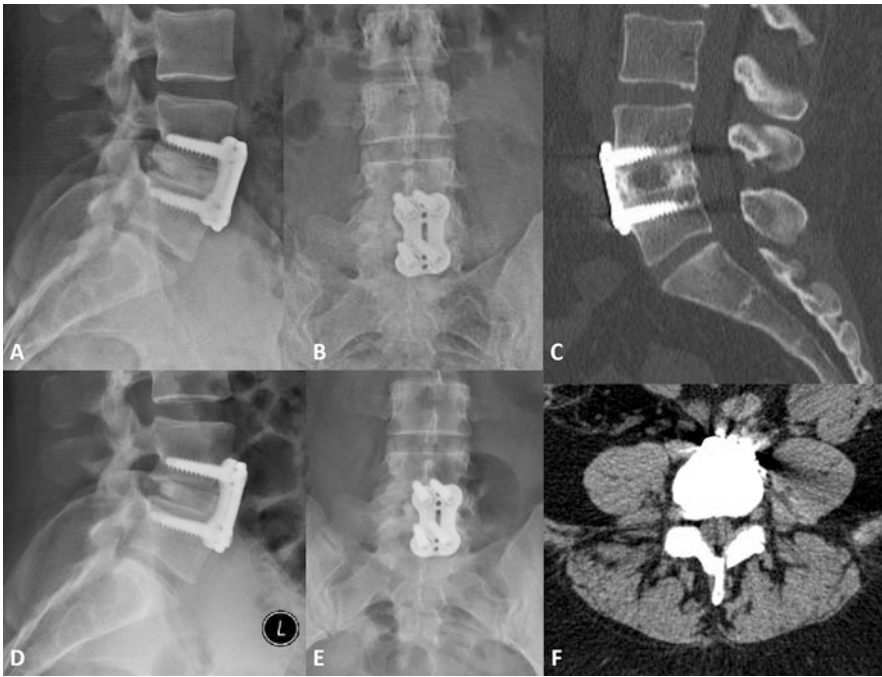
(a) and (b) 3-month postoperative lateral and posterior-anterior radiographs demonstrating good alignment of the construct. (c) and (f) mid-sagittal and L4/5 axial CT views at 44-month follow-up demonstrating solid fusion
